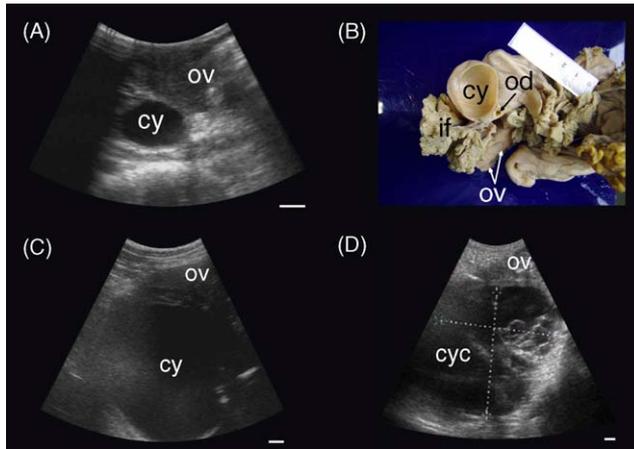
Ultrasonographic images and post mortem preparation of para-ovarian cysts in female white rhinoceroses. (A) A 3 cm para-ovarian cysts (cy) closely associated to the ovarian parenchyma (ov) in a non-cycling, southern white rhinoceros, no. 1242. (B) Cross-section of an ovarian cyst (cy) located in the serosa of the oviduct (od) and infundibulum in 9-year-old nulliparous female, no. 840. (C and D) Three-year development of a 9.5 cm para-ovarian cyst into a para-ovarian cystic complex (cyc) containing multiple septa in a nulliparous northern white rhinoceros, no. 789. (C) The small inactive ovary (ov) appears atrophic due to the mechanic pressure of the already large cystic structure. (D) After 3 years the cyst has further increased in size and complexity into a polycystic structure (pcy) of 12 cm. The atrophic ovarian parenchyma now shows areas of fibrosis. Scale bars represent 1 cm.
